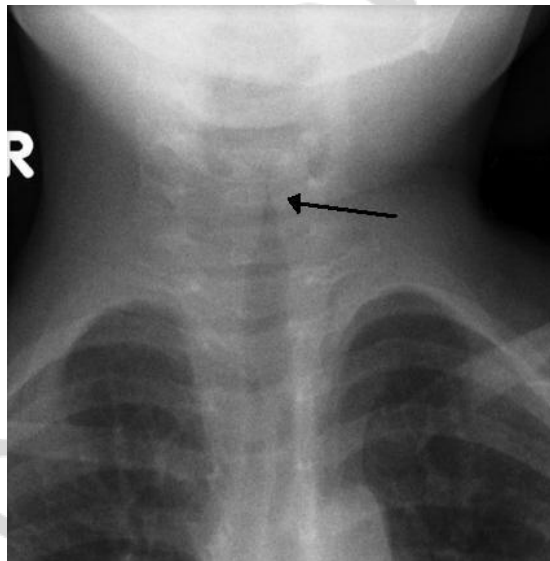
Anteroposterior x-ray of the neck in a child with croup demonstrating the steeple sign — narrowing of the the trachea. [Dr Frank Gaillard](#). Radiopaedia.org. Distributed under [the licence GFDL 1.3](#) (<https://www.gnu.org/licenses/fdl-1.3.html>) and [Creative Commons Attribution-Share-Alike 3.0](#) (<https://creativecommons.org/licenses/by-sa/3.0/>). https://commons.wikimedia.org/wiki/File:Croup_steeple_sign.jpg
